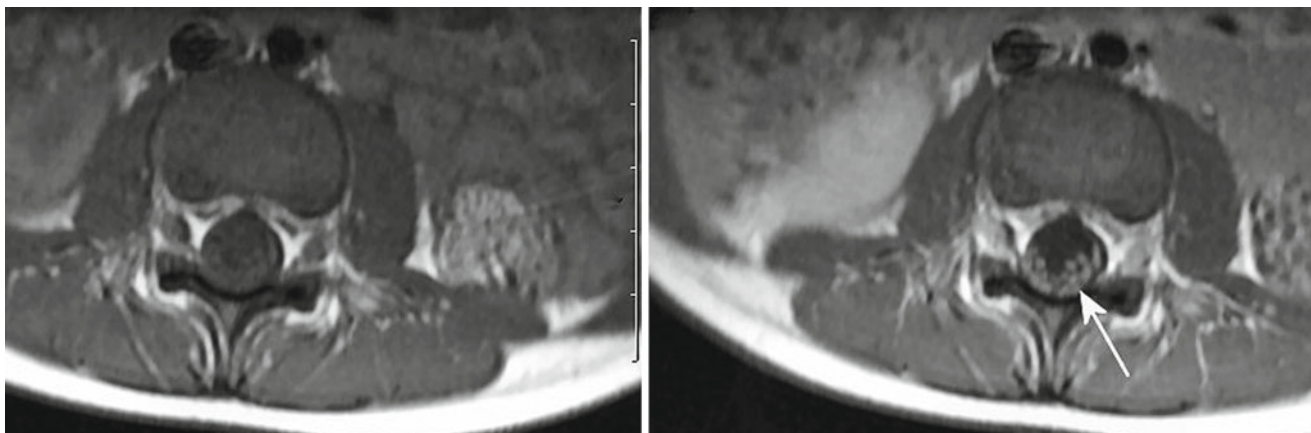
MRI of lumbar spine in a 4 year old with GBS showing enhancement of cauda equina. T1 weighted image (*left panel*) is normal while T1 weighted image following contrast shows enhancement of nerve roots (*white arrow, right panel*)
